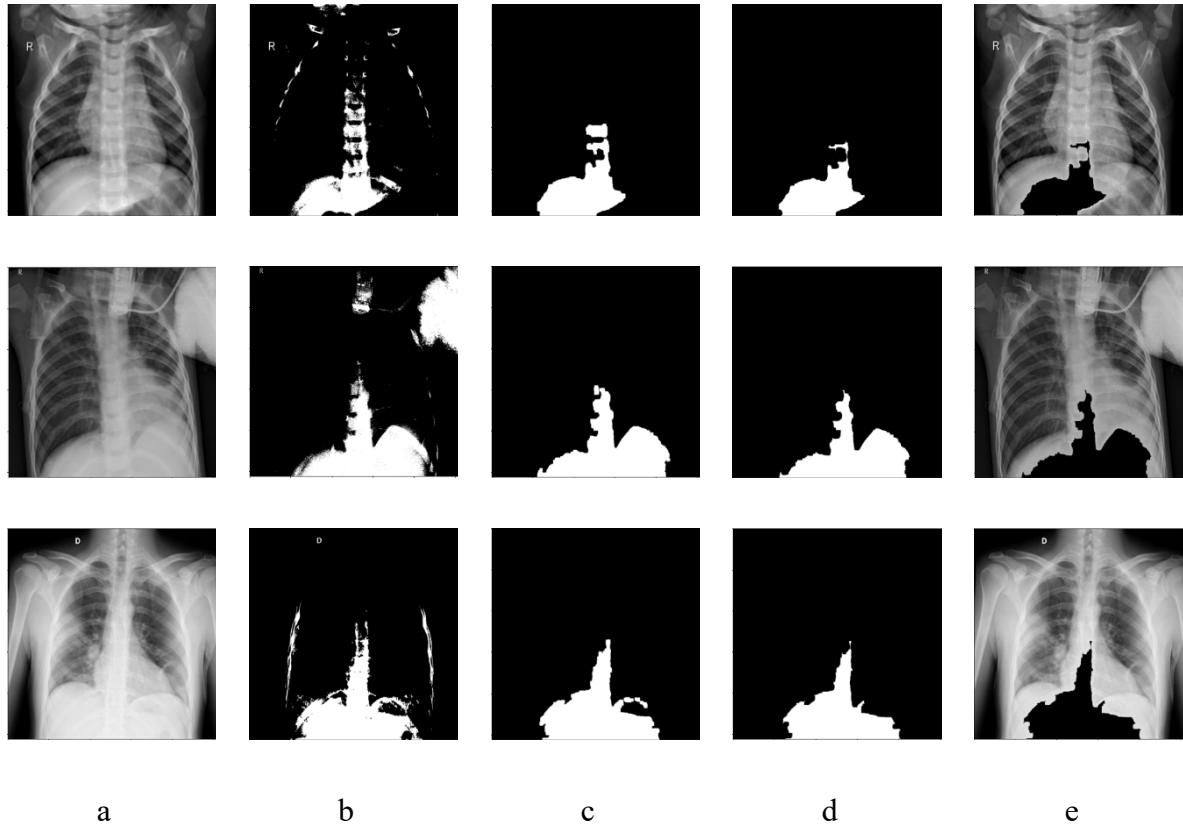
Example of chest X-ray images in three classes (top – normal, middle – community-acquired non-COVID-19 pneumonia, and bottom – COVID-19 infected pneumonia case). The figure also shows (a) the original Images, (b) the binary images after threshold, (c) images after selecting the biggest segmented region, (d) images after applying morphological filtering and (e) the original image after removing the majority part of diaphragm region ( $I_p$ ).
